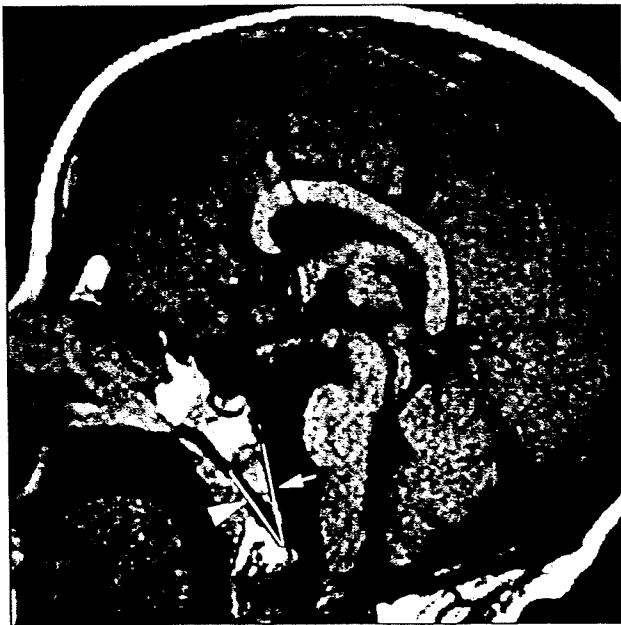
Measurement of the lengths of Ba-Es (arrow) and Ba-Xs (arrowhead) on a T1-weighted sagittal image (patient 3).
